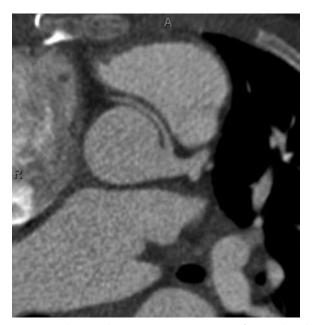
Axial maximal intensity projection image of a gated cardiac CT reveals a malignant course of the right coronary artery, taking origin from the left coronary artery and coursing between the aorta and pulmonary trunk.
